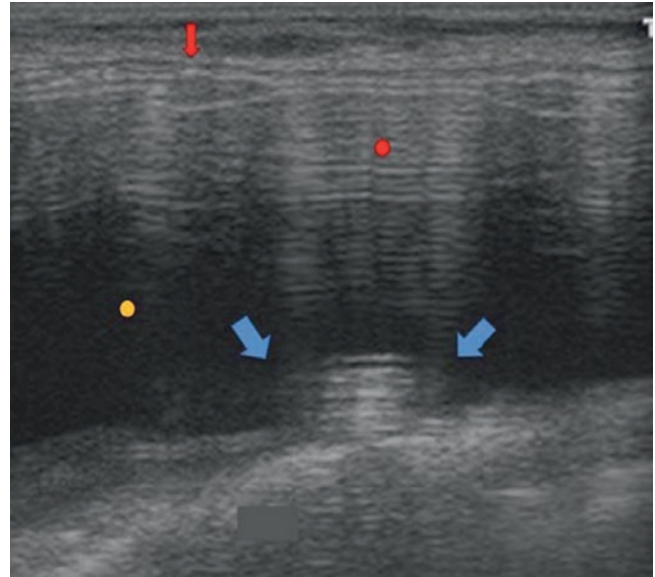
Ultrasound appearance of a saline solution implant: Oval and anechoic mass identical to the silicone implant in Fig. 21.17 with a double hyperechoic line corresponding to the elastomer (*red arrow*) and reverberation artifact (*red dot*). The saline solution inside the implant presents an anechoic appearance (*yellow dot*). The only way to differentiate this implant from the silicone implant is to appreciate the filling valve in its posterior aspect (*blue arrows*). Sometimes it is not well seen with ultrasound because of the depth of the posterior margin of the implant. This image appeared in the *European Aesthetic Plastic Surgery Journal* (number 12). Reproduced with permission from the *Asociación Española de Cirugía Estética Plástica*.
